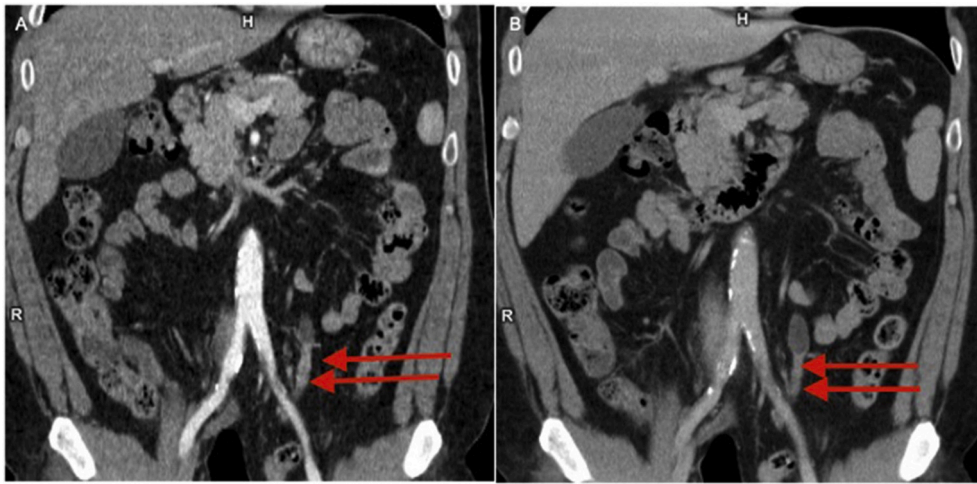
Restaging contrast-enhanced CT coronal images performed after two months of neoadjuvant chemotherapy for a urothelial bladder cancer revealed a partial reduction of the bladder lesion. However, the A) angiographic and B) nephrographic phases of the scan reveal two areas of slight wall thickening in the left ureter (arrows). These regions of slight wall thickening were unaltered compared to the staging CT scan and deemed equivocal for malignancy.
